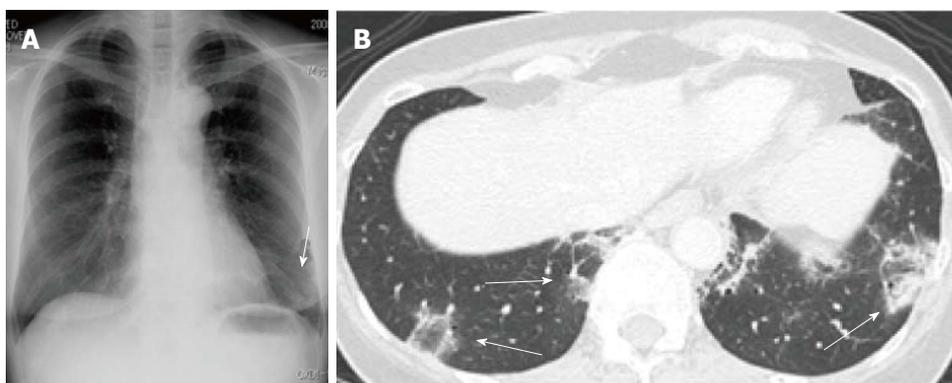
Cryptogenic organizing pneumonia with reversed halo sign in a woman in her 50s: courtesy of Dr. Takahiro Haruyama and Dr. Asako Yamamoto, attending radiologists at the department of Radiology, Teikyo University School of Medicine. A: Chest radiograph shows an ill-defined consolidation in the left lower lung field (arrow); B: Thin-section computed tomography reveals bibasilar ground-glass opacity with a ring of consolidation (reversed halo sign) (arrows).
